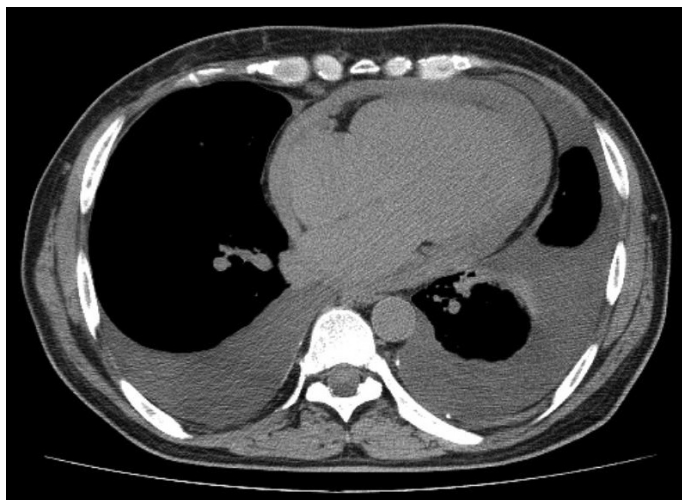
Transaxial CT image of the thorax shows the fluid collections within the pericardial sleeves (up to 14 mm) and bilateral pleural spaces
